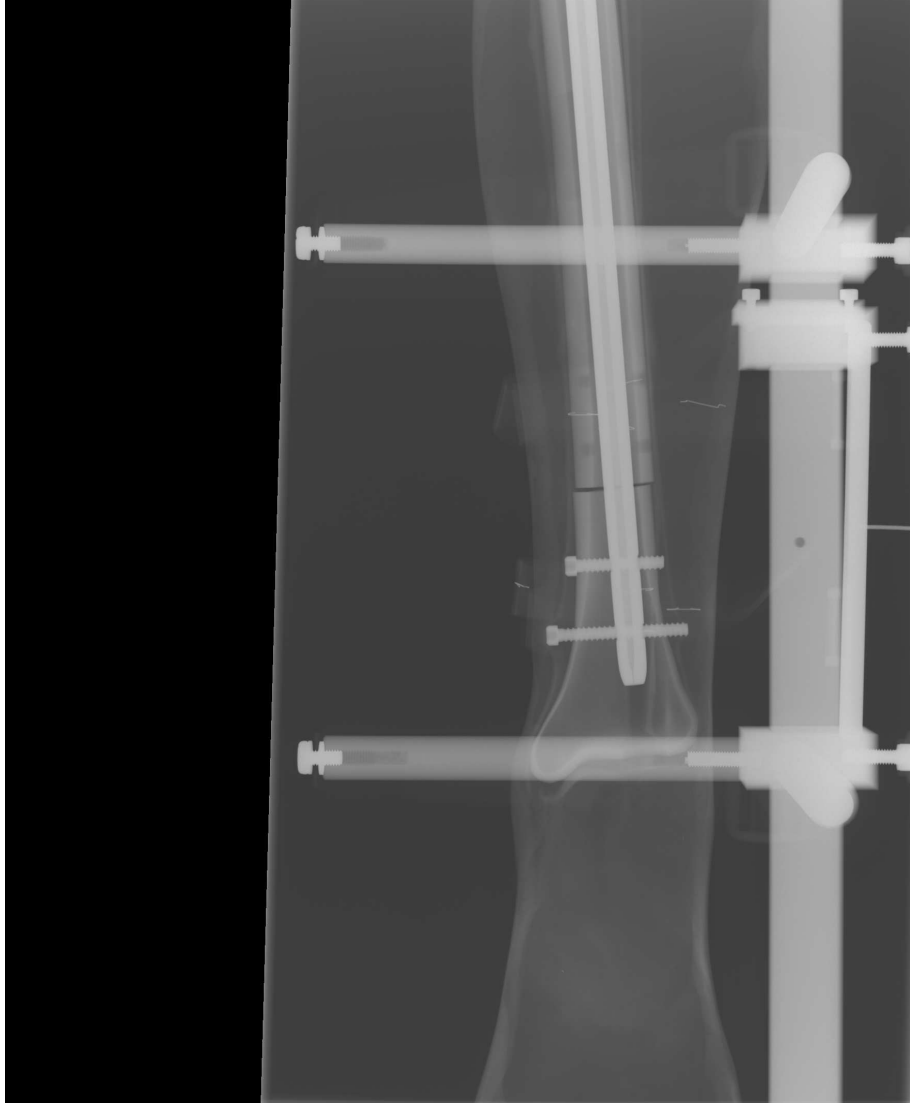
Image of the nailed distal fracture in the soft tissue leg placed in the X-ray frame.
